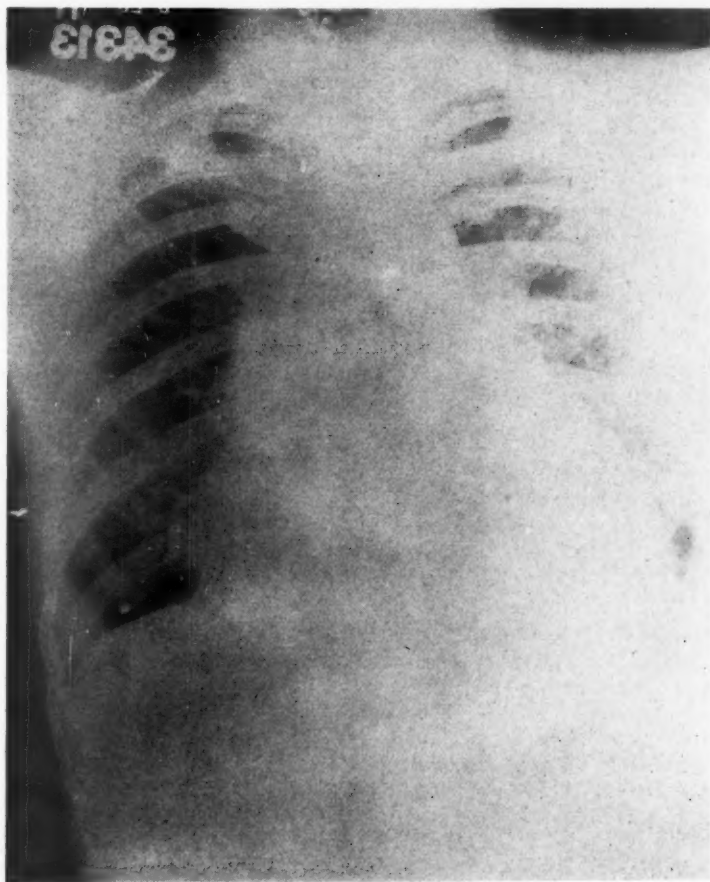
Roentgenogram of chest taken Aug. 28, 1942, showing marked generalized enlargement of the heart, with especial prominence of the right auricular area.
